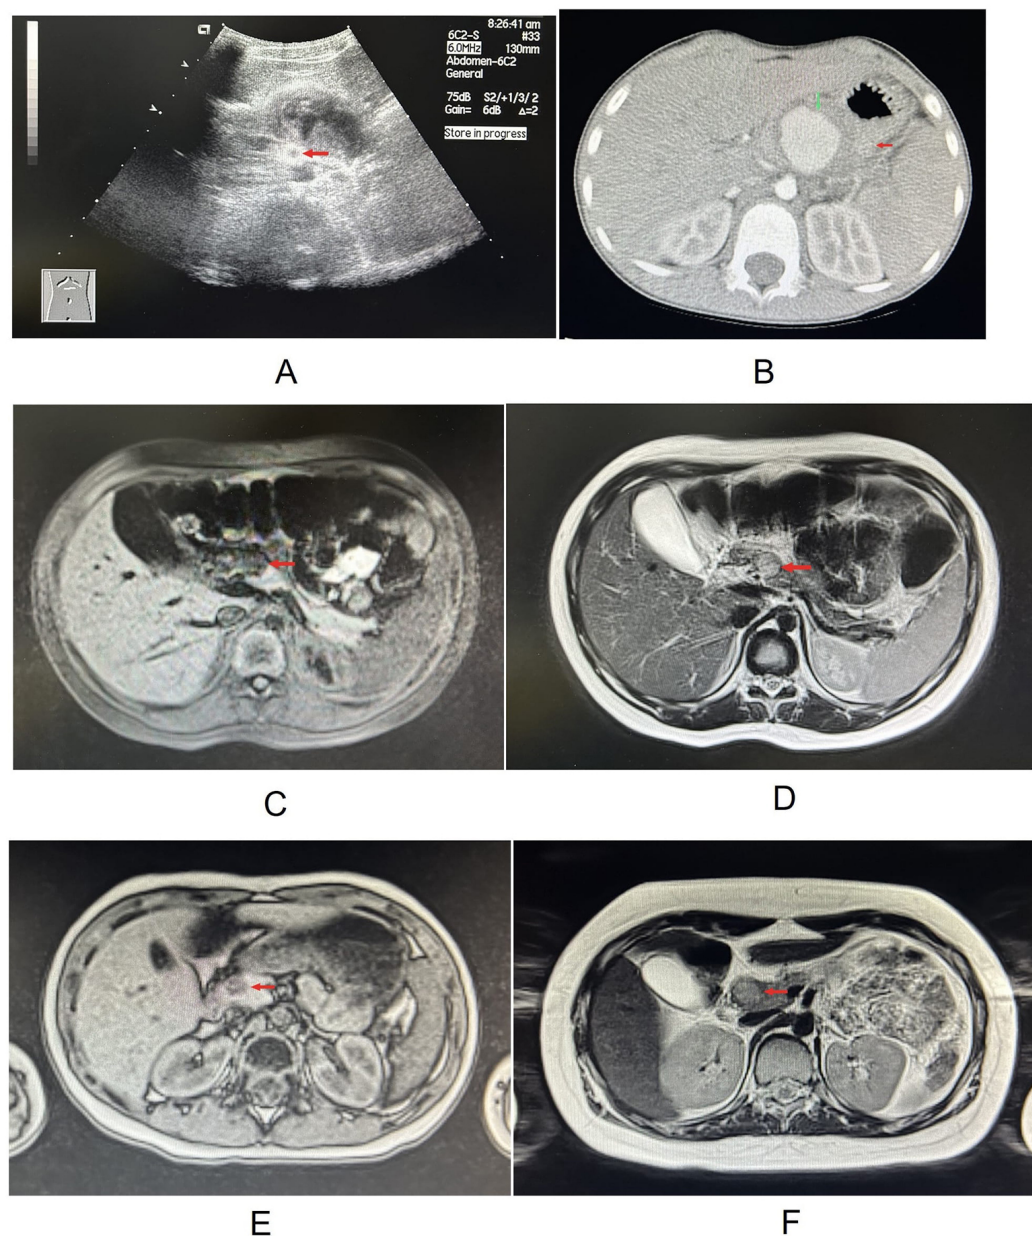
Radiographic features of insulinoma in pediatric patients. (A) Ultrasound scan of the pancreas (patient 3): The red arrow indicates the insulinoma located at the neck of the pancreas. (B) Computed tomography (CT) scan of the pancreas (patient 2): The green arrow highlights a 6 cm pseudoaneurysm caused by splenic artery dilation at the body of the pancreas. Additionally, the red arrow denotes the presence of an insulinoma at the tail of the pancreas. (C) Magnetic resonance imaging (MRI) T1-Weighted Imaging Sequence 1 (T1W1) result (patient 4): The red arrow indicates a 1.5 cm round-shaped lesion with reduced enhancement at the body of the pancreas. (D) MRI T2-Weighted Imaging Sequence 1 (T2W1) result (patient 4): The image shows a highly enhanced, round-shaped lesion measuring 1.5 cm at the body of the pancreas, as indicated by the red arrow. (E) MRI T1W1 result (patient 5): The red arrow indicates a 0.8 cm round-shaped lesion with reduced enhancement at the head of the pancreas. (F) MRI T2W1 result (patient 1): The image shows a highly enhanced, round-shaped lesion measuring 3 cm at the head of the pancreas, as indicated by the red arrow.
